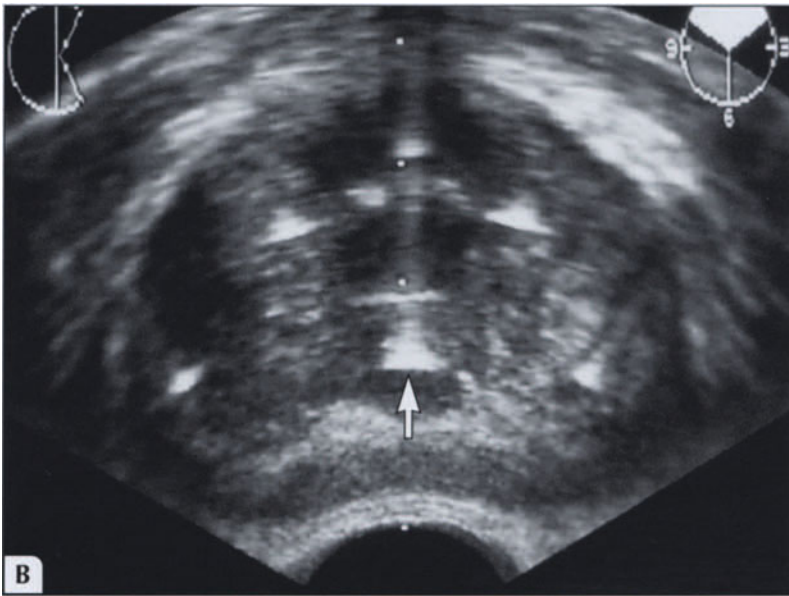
(Continued) The needle locations are seen as bright dots on ultrasound imaging (B, arrow). The exact positioning of each needle and resulting probe is determined at this point. Each needle is advanced up to the desired location, usually up to the base of the prostate. Usually five to six needles are inserted, two anteromedially, two posterolaterally, and one or two posteriorly.
